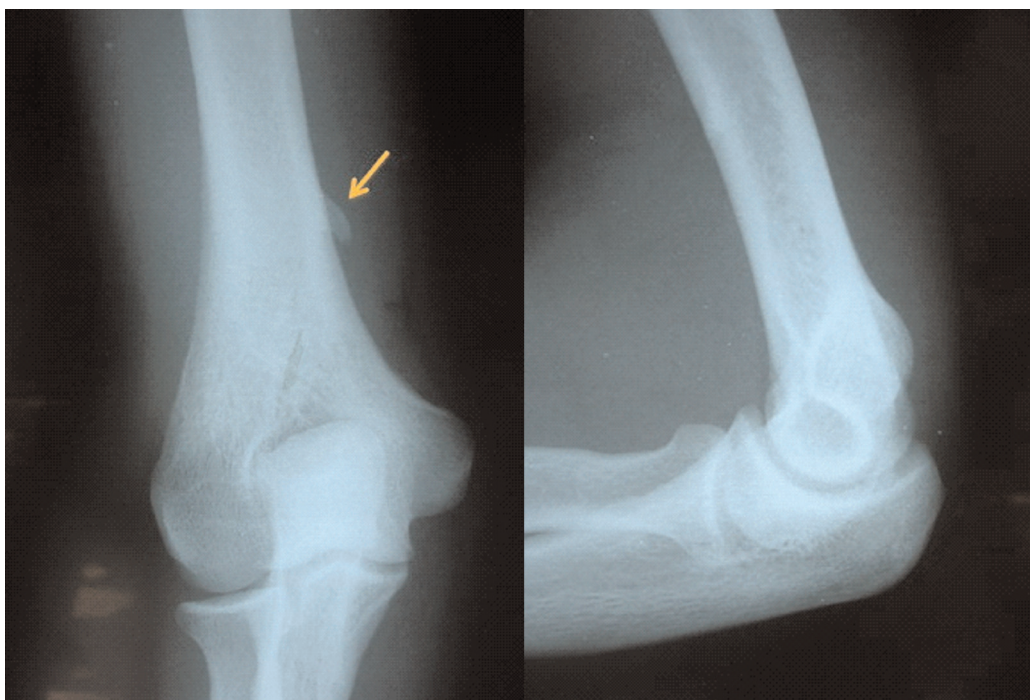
Radiographs of right elbow showed a supracondylar process (arrow).
